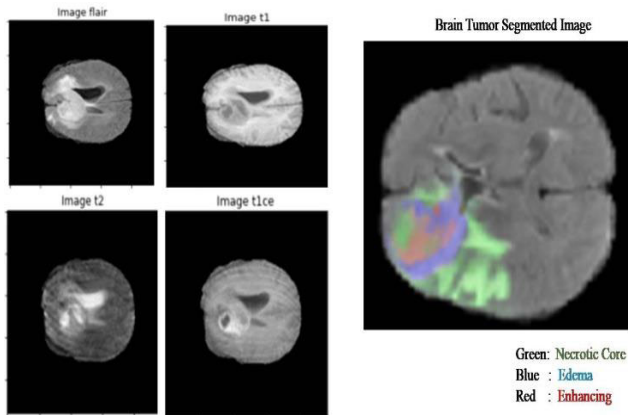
(a) Sample MRI of FLAIR, T1, T1-CE, T2 images from BraTS2020 dataset. (b) UNet++ brain tumor segmented image with labels.
